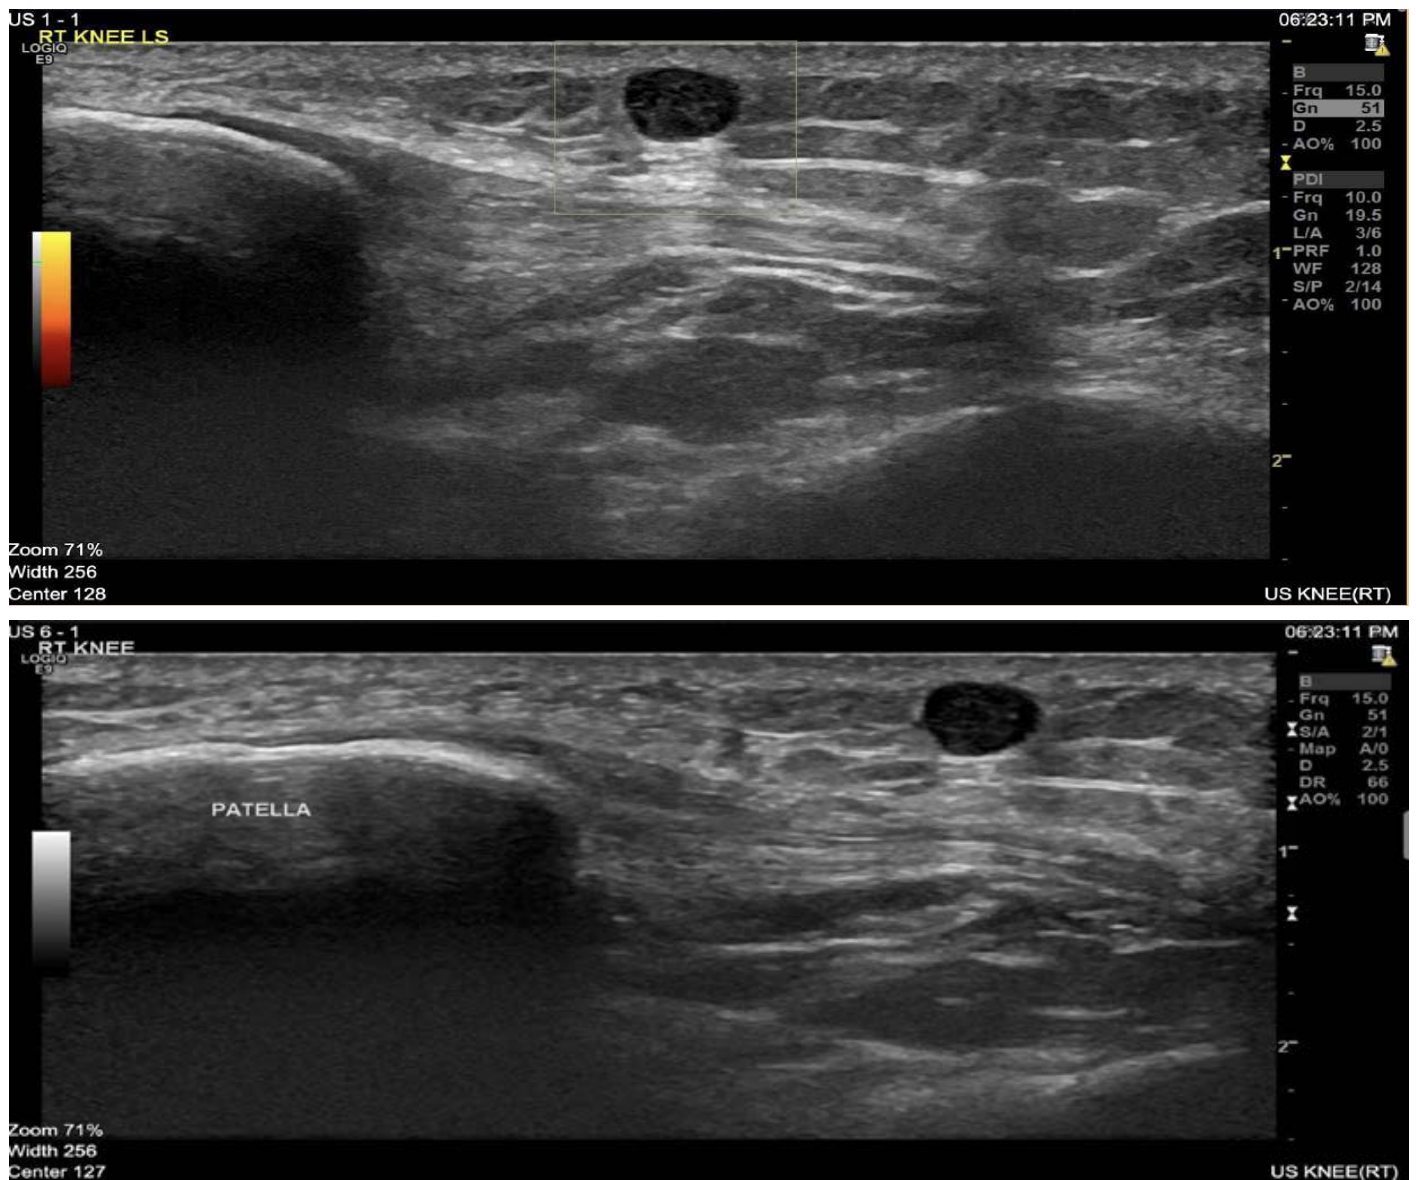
A-B: Ultrasonography of the Right Knee Joint - Pre-operative ultrasonography of the right knee joint showed a right infra-patellar small subcutaneous nodule measuring 4.8 x 3.6 mm in diameter showing hypoechoic contents with no vascularity. Likely benign in nature, with no intra-muscular or intra-articular extension
